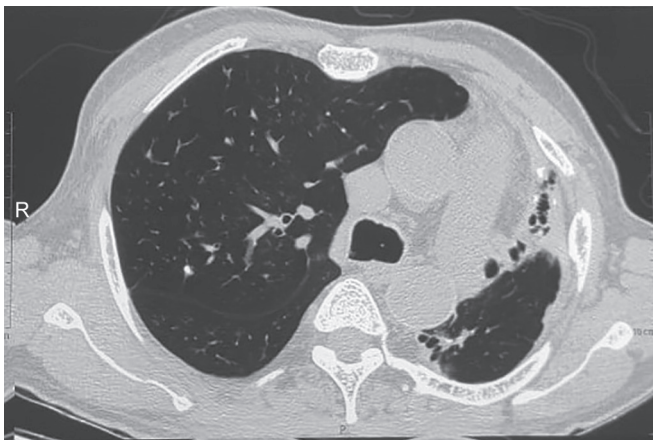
High resolution computed tomography thorax showing diffuse fibrobronchiectatic changes in the left upper lobe with compensatory hyperinflation of right upper lobe and retrosternal herniation
